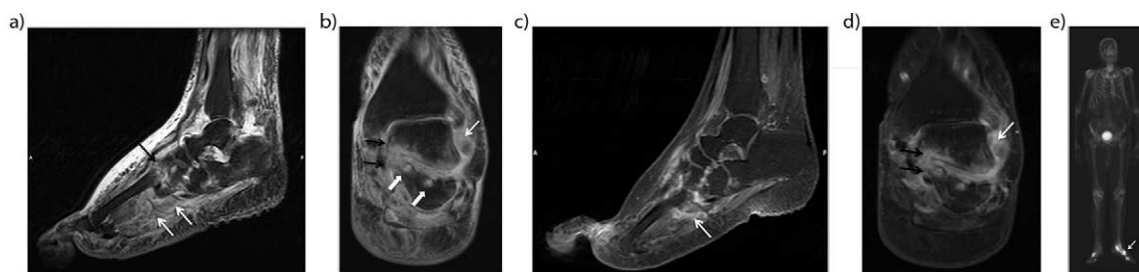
Acute neuroarthropathy in an 80-year-old man with long-standing diabetes. Sagittal (a), and coronal (b) T2-weighted fat-saturated images demonstrated massive soft tissue edema in subcutaneous and periarticular region and periarticular bone marrow edema around the Lisfranc joints (black arrow) and posterior subtalar joint. Also note tiny cysts (solid white arrows) along the posterior subtalar joint. Sagittal (c) and coronal (d) post-contrast T1-weighted fat-saturated images demonstrated strong enhancement in the periarticular bone marrow (black arrows) and in the soft tissue planes (white arrows). Late phase bone scintigraphy (e) reveals an increased uptake along the affected bone and joints (arrow).
